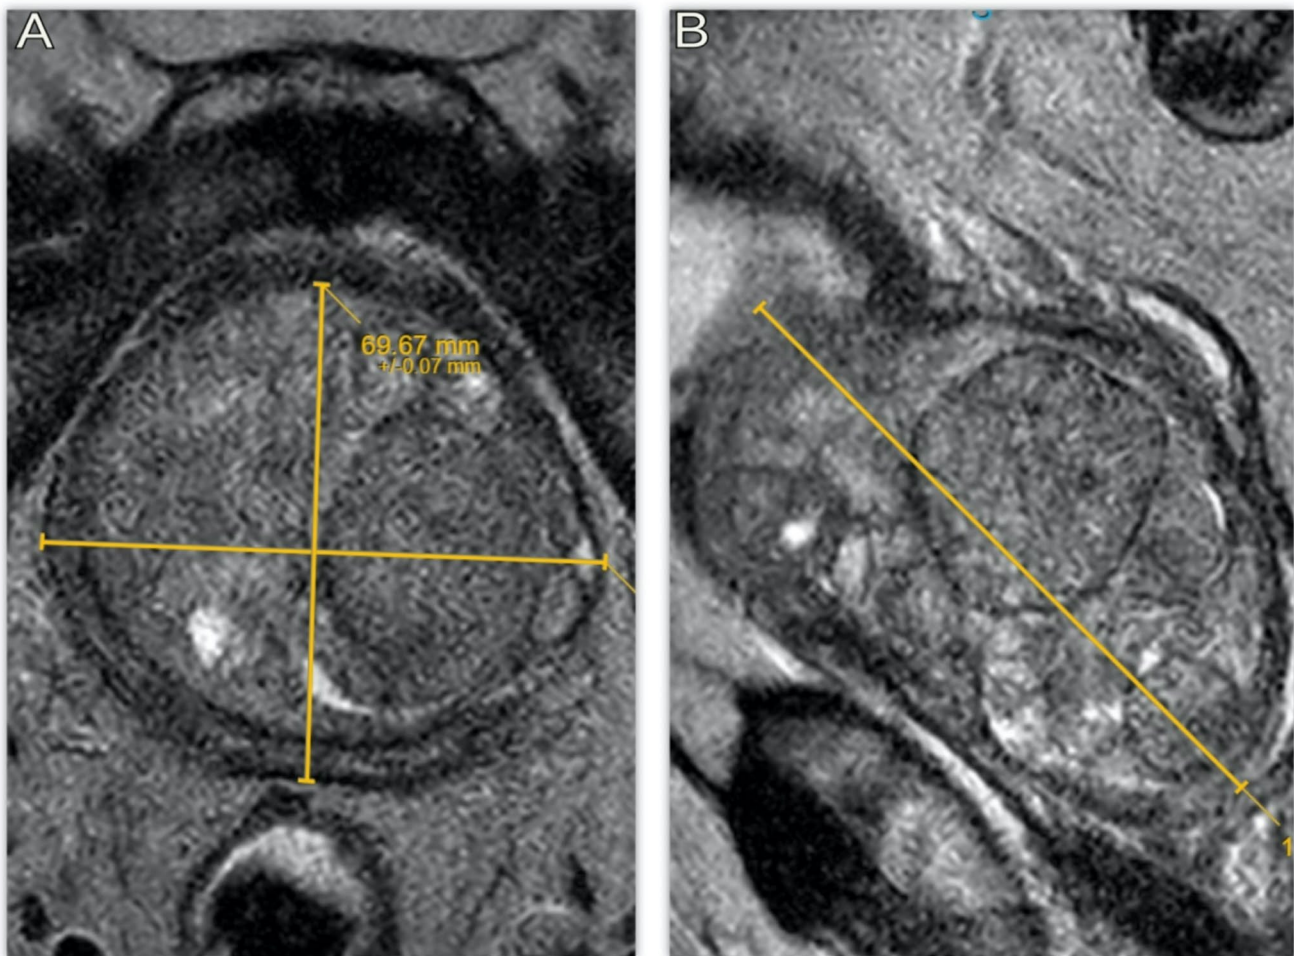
Magnetic Resonance Imaging in the transverse (A) and sagittal (B) planes of a patient with a prostate volume exceeding 200 cc
